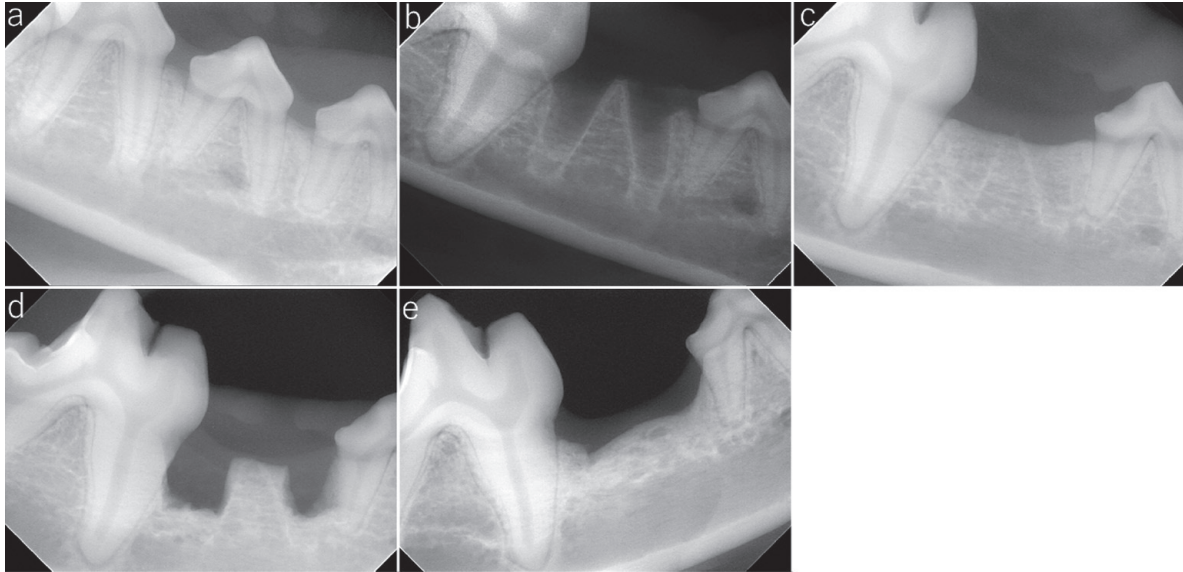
Radiograph of mandibular right fourth premolar and first posterior molar. a: Preoperative condition of the mandibular right fourth premolar and mandibular right first posterior molar. b: Immediately after extracting the mandibular right fourth premolar. c: Eight weeks after extraction. d: Immediately after creating a experimental single-walled bone defect model distal to the mandibular right third premolar and proximal to the mandibular right first posterior molar. c: Healing of the extraction wound eight weeks after extraction. d: Immediately after creating the experimental single-walled bone defect model in the centrum of the mandibular right third premolar and at the proximal portion of the mandibular right first posterior molar. e: Eight weeks after creating the experimental single-walled bone defect model. The mandibular right alveolar bone shows bone resorption and partial reduction of the alveolar crest.
